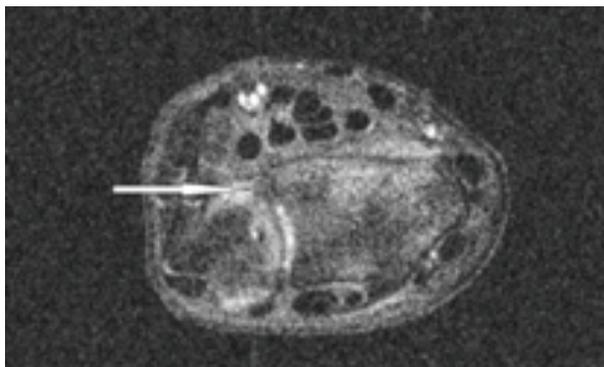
TFCC 1D lesion – radial avulsion of TFCC disc proper (MRI, transverse plane, STIR).
